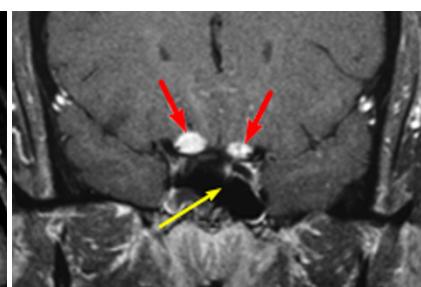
Contrast-enhanced fat-saturated T1-weighted coronal image with enhancement and thickening of both optic nerves in prechiasmatic segment (upper arrows). Lower arrow points the sphenoid sinus.
